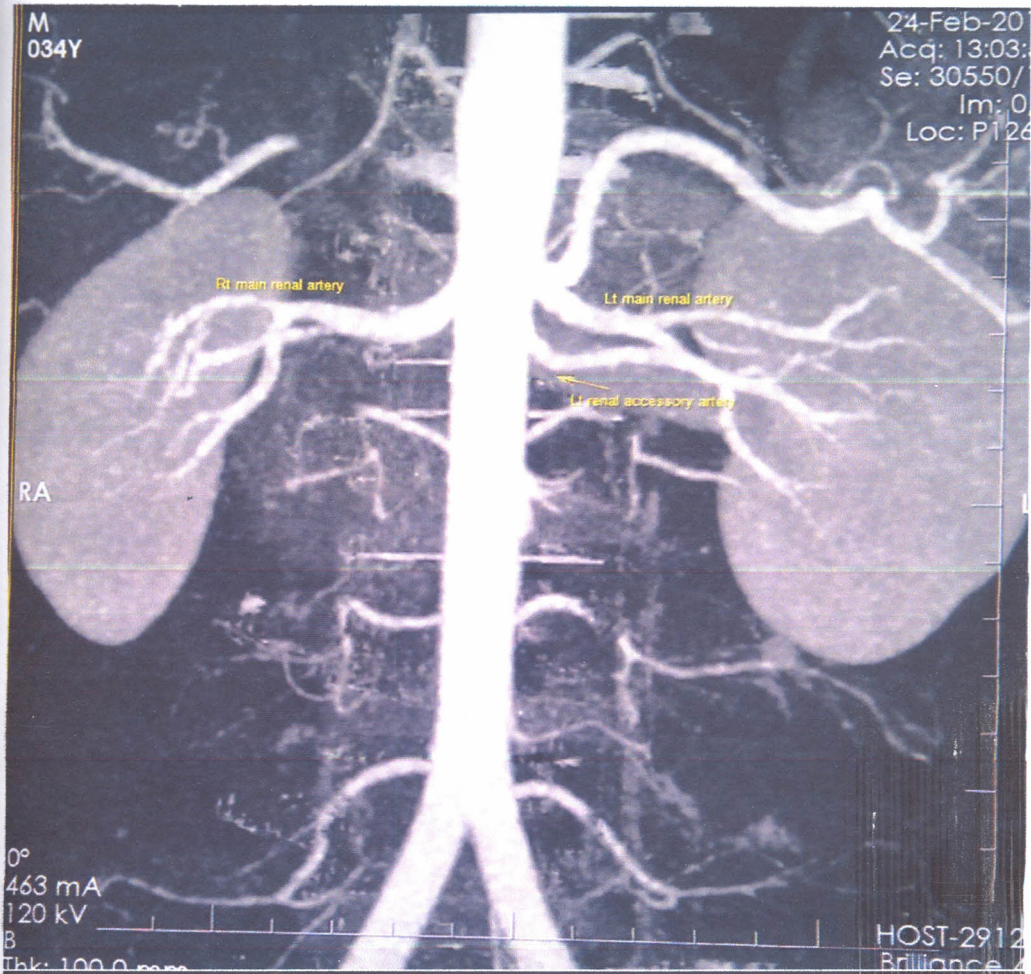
MIP Renal CTA of an adult 34 years male potential donor with left accessory renal artery.
